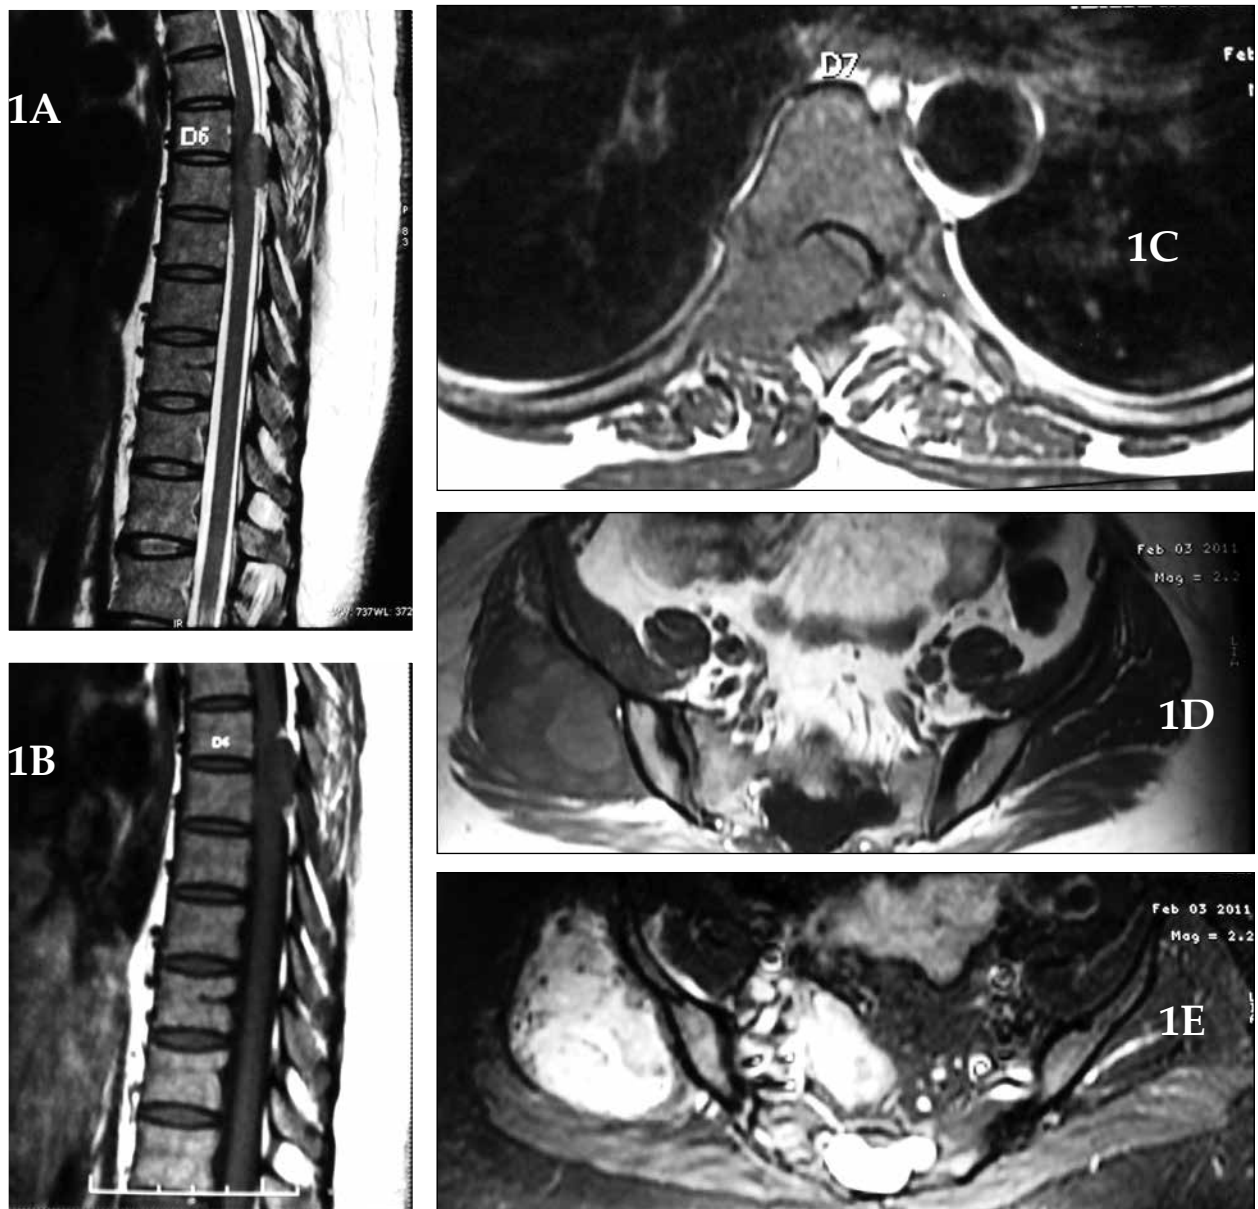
C: T2 and T1 weighted MRI images depicting the tumor involving the bodies and posterior elements of D6-7 vertebrae. 1D - E: T2 and T1 weighted MRI images of the right pelvic location of tumor involving the glutei and extending medially across the ilium
